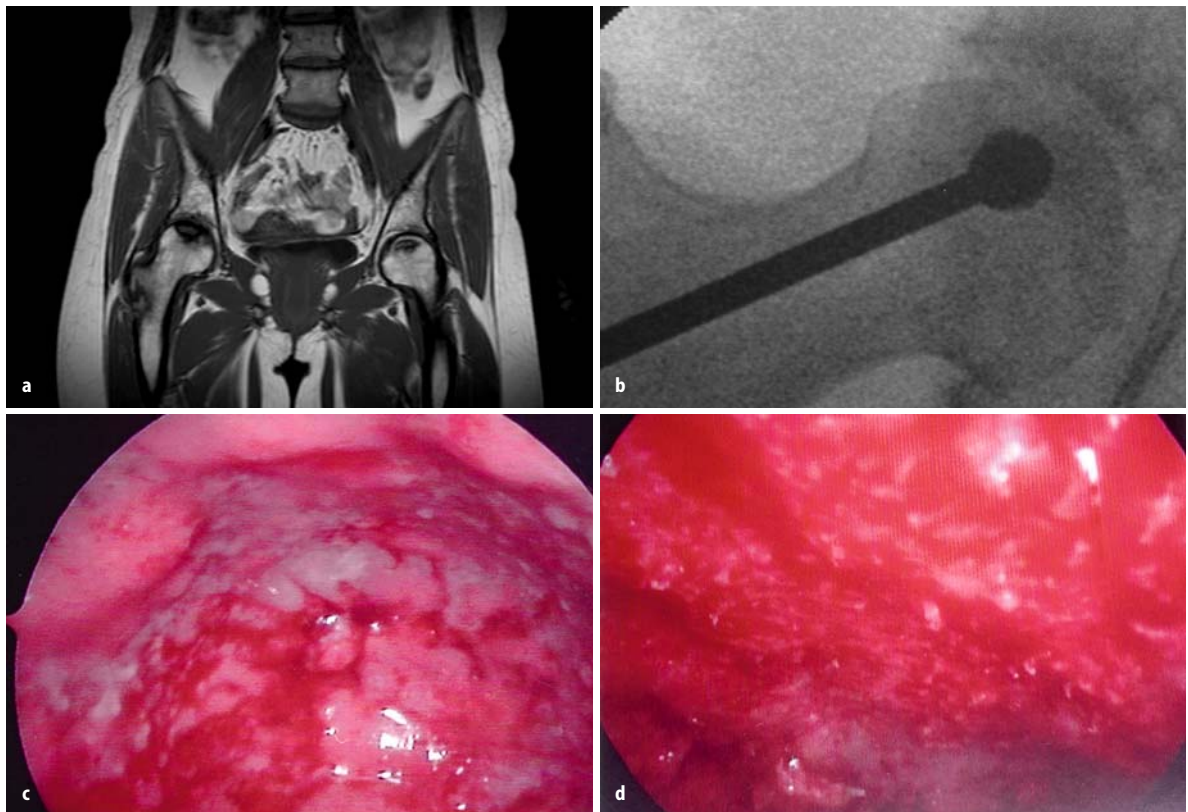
a Femoral head necrosis, grade II on the right side and grade I on the left side, in a 20-year-old woman after massive corticosteroid treatment. The symptomatic right hip was operated on. b Peroperative X-ray to control the removal of the necrotic bone. c Primary peroperative endoscopy through the drill hole. White necrotic bone is seen on top of the drill hole. d Endoscopic view after removing the dead bone. Bleeding bone is seen over all the defect
